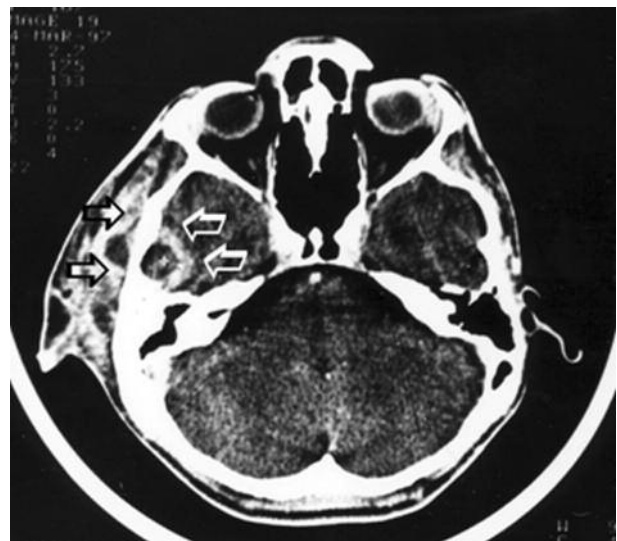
CT demonstrates abscess (star) in right temporal brain lobe (arrows)
